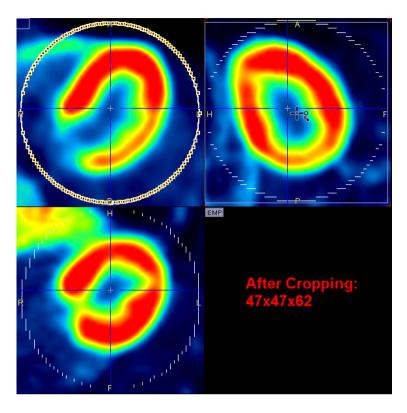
Image cropping is particularly useful as a pre-processing step to image registration. When matching a dynamic series to high-resolved MRI or CT images as a reference, it is highly recommended to crop the reference to the organ of interest before the registration. Hereby, the RAM requirements are reduced by factors without losing information, and processing speed is improved accordingly.
